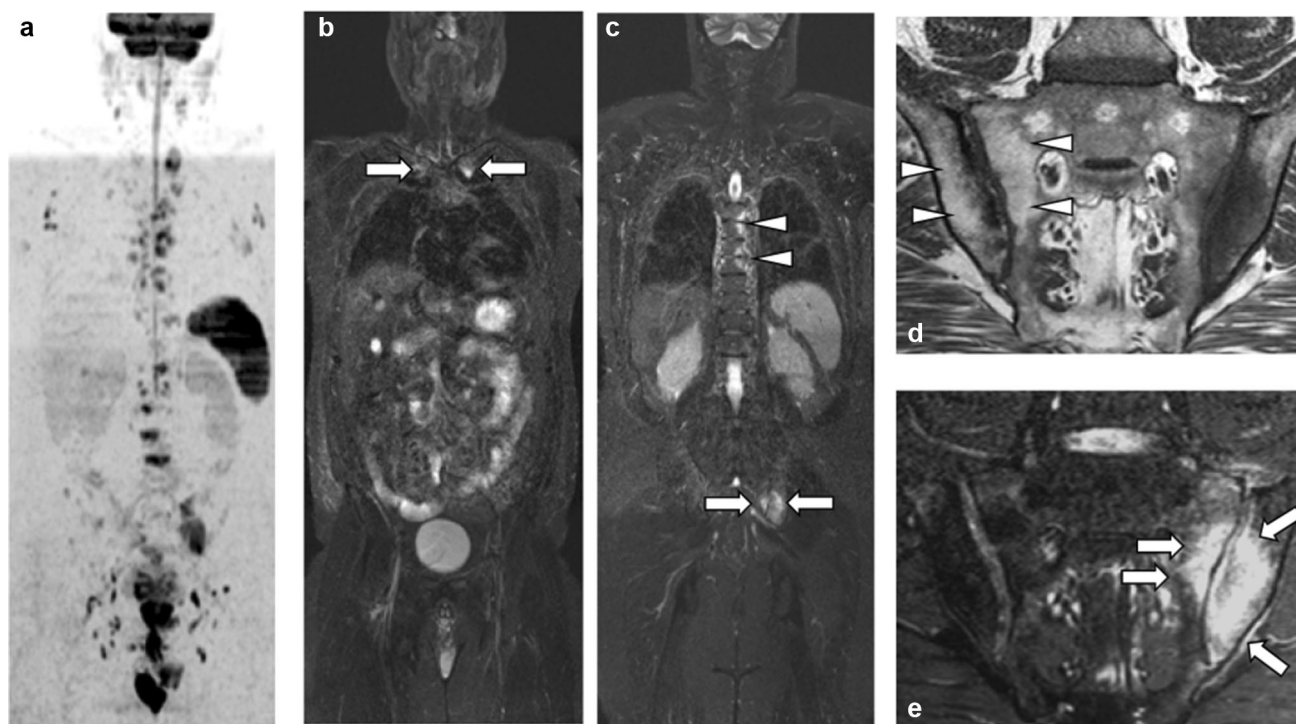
WBMRI images in a 50-year-old male patient with long history of diffuse pain but newly diagnosed AS. Whole-body DWI sequence (MIP view, inverted grey scale) (a) shows multifocal abnormalities, mainly involving disco-vertebral junctions, sterno-clavicular joints and SIJ (note that the spleen, axillar and inguinal lymph nodes, and testes are “physiological” observations on DWI images). Coronal STIR MR images (b, c) show high signal intensity
